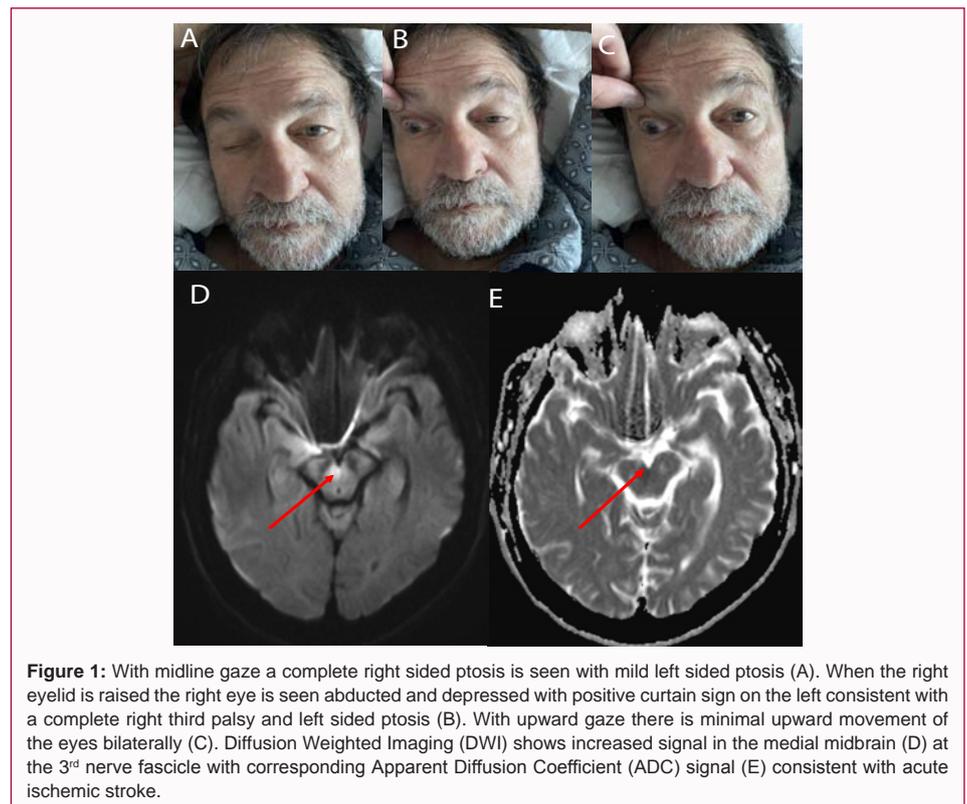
With midline gaze a complete right sided ptosis is seen with mild left sided ptosis (A). When the right eyelid is raised the right eye is seen abducted and depressed with positive curtain sign on the left consistent with a complete right third palsy and left sided ptosis (B). With upward gaze there is minimal upward movement of the eyes bilaterally (C). Diffusion Weighted Imaging (DWI) shows increased signal in the medial midbrain (D) at the 3rd nerve fascicle with corresponding Apparent Diffusion Coefficient (ADC) signal (E) consistent with acute ischemic stroke.
